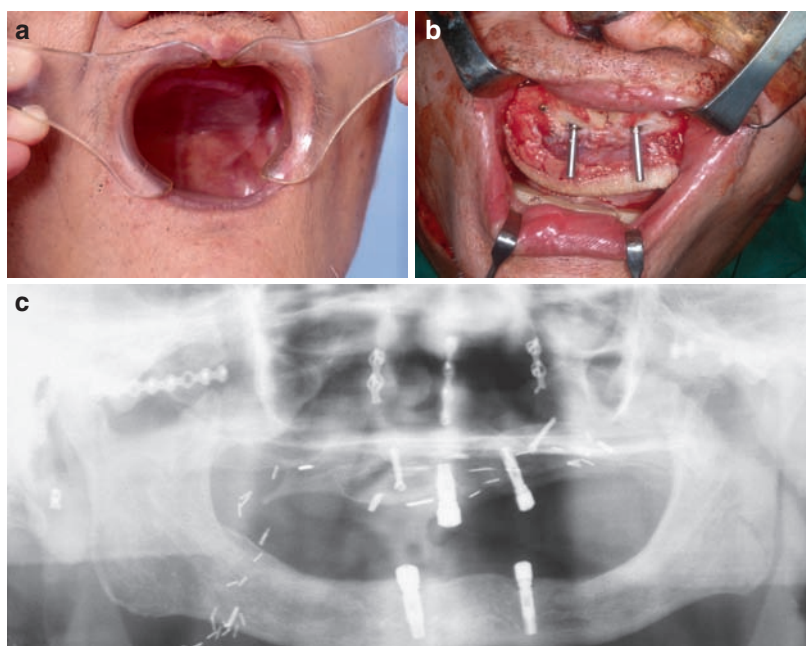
Traumatic segmental maxillary defect reconstructed with fibula osteoseptocutaneous flap and immediate osteointegration teeth. (a) Traumatic segmental maxillary defect. (b) Bone contouring and osteointegration teeth implantation during reconstruction with a fibula osteoseptocutaneous flap. (c) Final x-ray appearance.
